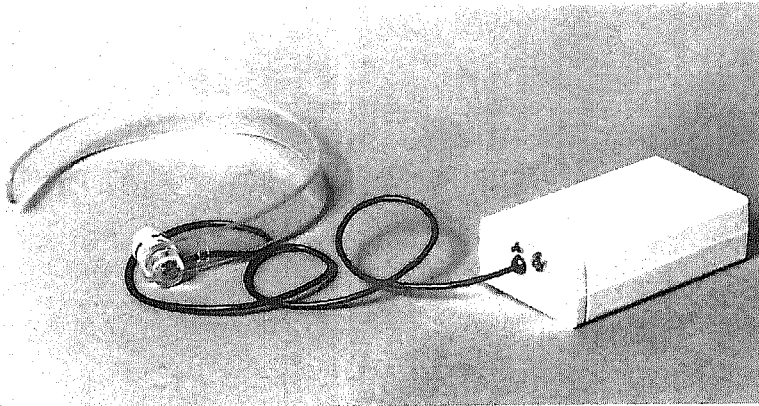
The ultrasound generator.
